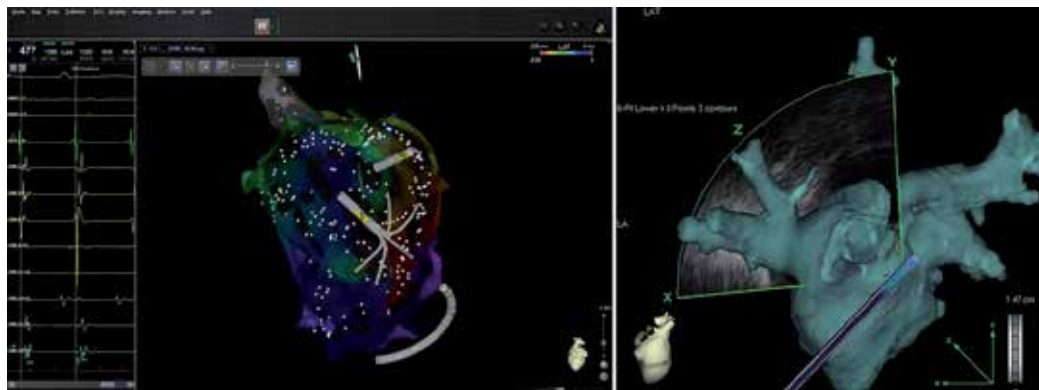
BioSense Webster has recently released (left) a multi-electrode mapping version of its 3D cardiac mapping system, and (right) a platform to merge ultrasound data of the heart [37].
